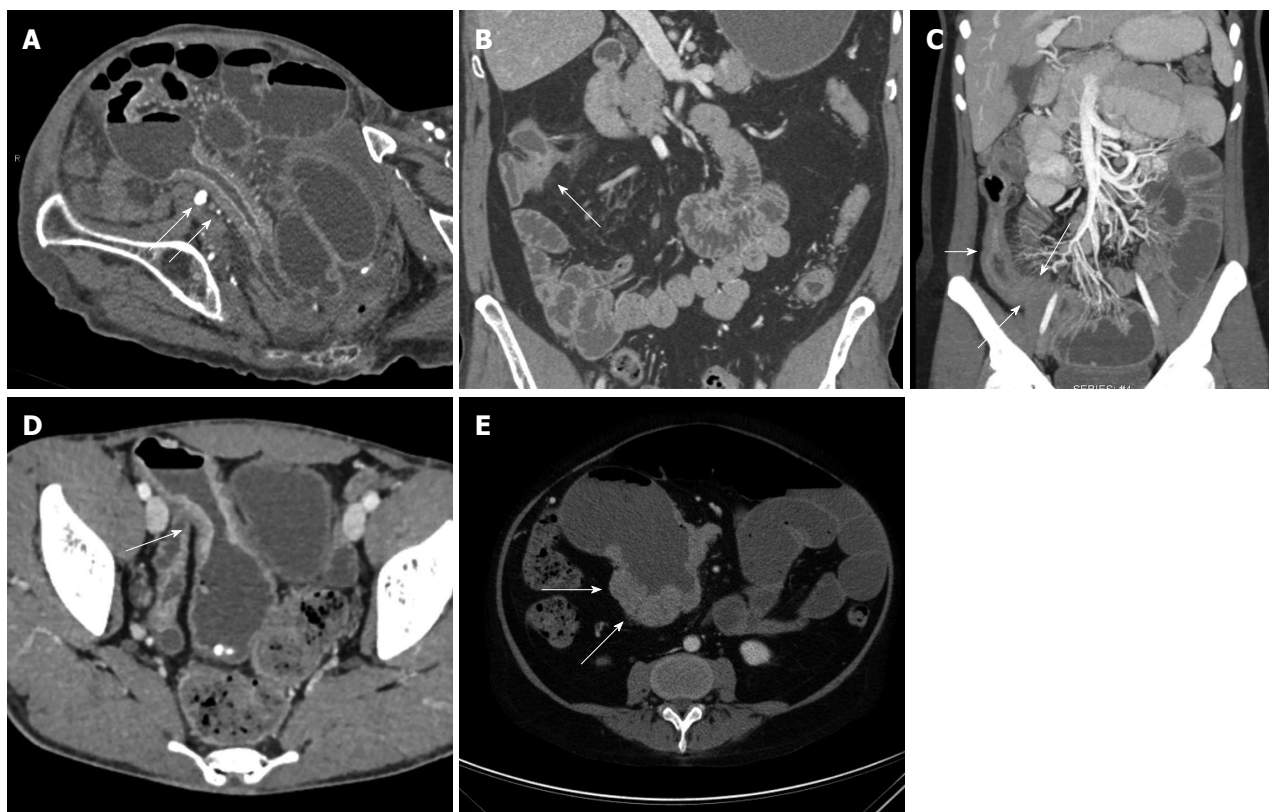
Bowel-related complications of Crohn's disease. A: Eighty-four-year-old who presented with abdominal pain. Axial contrast-enhanced image demonstrates multiple dilated loops of small bowel, in keeping with a small bowel obstruction. This image also demonstrates a long segment of bowel wall thickening and mucosal hyperemia with luminal narrowing (arrows). Given the patient's age, this was originally thought to represent a neoplastic or ischemic stricture, but was found to represent late-onset Crohn's disease after surgery; B: Forty-nine-year-old male with Crohn's disease. Coronal volume rendered computed tomography image demonstrates a short segment stricture and focal thickening of the hepatic flexure of the colon, with minimal adjacent induration, but no significant mesenteric hyperemia. This was thought to be a chronic-appearing stricture. Colonoscopy was performed to exclude an underlying neoplasm, and the patient was found to have a chronic stricture in this location without acute inflammation or evidence of tumor; C: Twenty-four-year-old female with Crohn's disease. Coronal volume rendered image demonstrates several dilated loops of small bowel in the left abdomen, with a discrete transition point (long arrows) in the distal ileum, at the site of a long segment of narrowed, hyperemic, thickened, inflamed small bowel (short arrow); D: Twenty-five-year-old male with Crohn's disease. Axial contrast enhanced image demonstrates thickening of a loop of small bowel in the pelvis, with dilatation proximal to the site of stricturing. Given the irregular thickening (arrow) at this site, the possibility of a malignancy could not be excluded. As a result, the patient underwent surgical resection and was found to have a small bowel adenocarcinoma; E: Fifty-one-year-old female with a history of Crohn's disease. Axial image demonstrates nodular soft tissue thickening (arrows) surrounding an aneurysmally dilated loop of bowel in the right abdomen. This was found to represent B-cell lymphoma following surgical resection.
